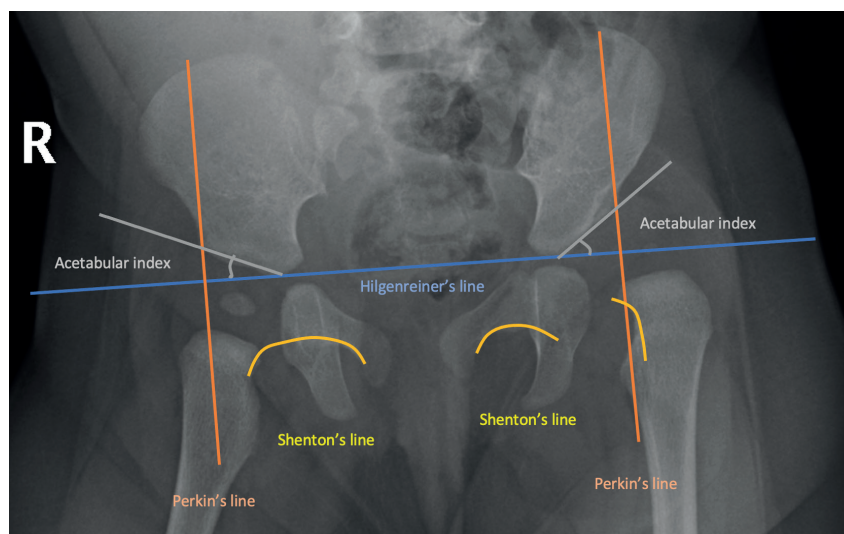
An antero-posterior radiograph of both hips of a 6-month-old infant, showing a normal right hip (with the femoral epiphysis in the inferomedial quadrant and intact Shenton's line) and a dislocated left hip (with the femoral epiphysis in the superolateral quadrant and a disrupted Shenton's line).
